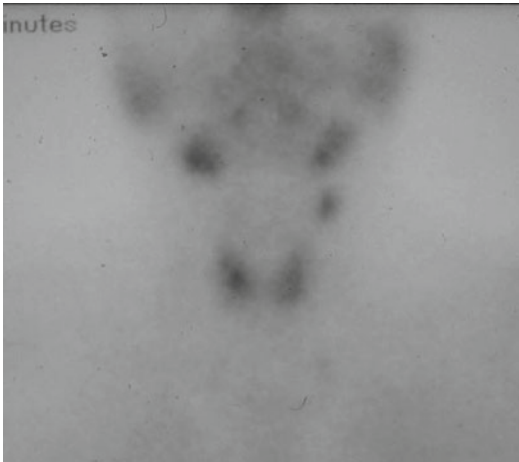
Undescended abnormal left inferior (P III) parathyroid gland identified on ^{99m}Tc -sestamibi scintigraphy. At surgery, this gland was found on the antero-medial side of the carotid sheath and was associated with a small amount of thymic tissue. A defect of congenital migration of the parathymus complex was responsible for this high ectopia in the neck
